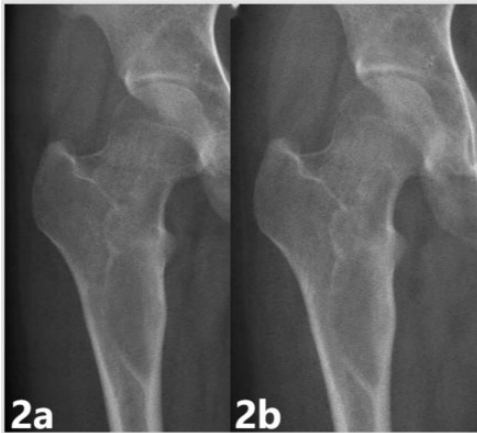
Radiographs for a patient with fibrous dysplasia of the proximal femur who did not develop a fracture. Radiographs obtained (a) at the time of diagnosis and (b) when the patient was rechecked. There was no fracture of the proximal femur.
